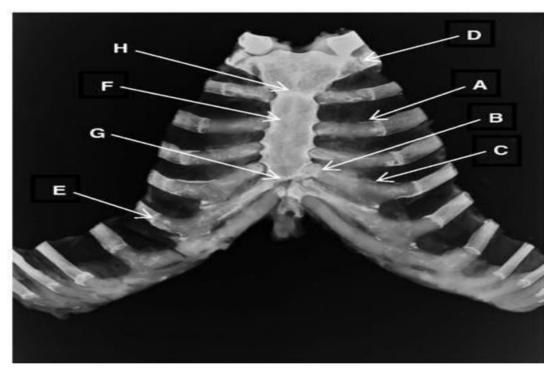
Exemplary chest plate X-ray image and score (Monum et al., 2017)
